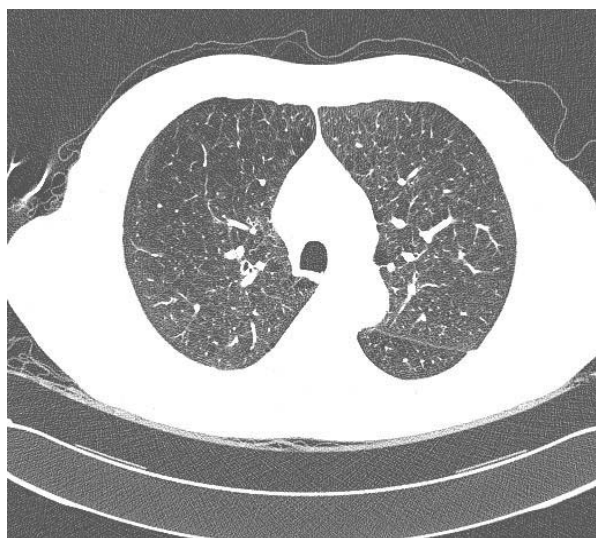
HRCT scan of the chronic obstructive lung disease demonstrates the decreased attenuation areas without definable walls in the right lung fields. Vascularity is also decreased in the affected lung fields.
